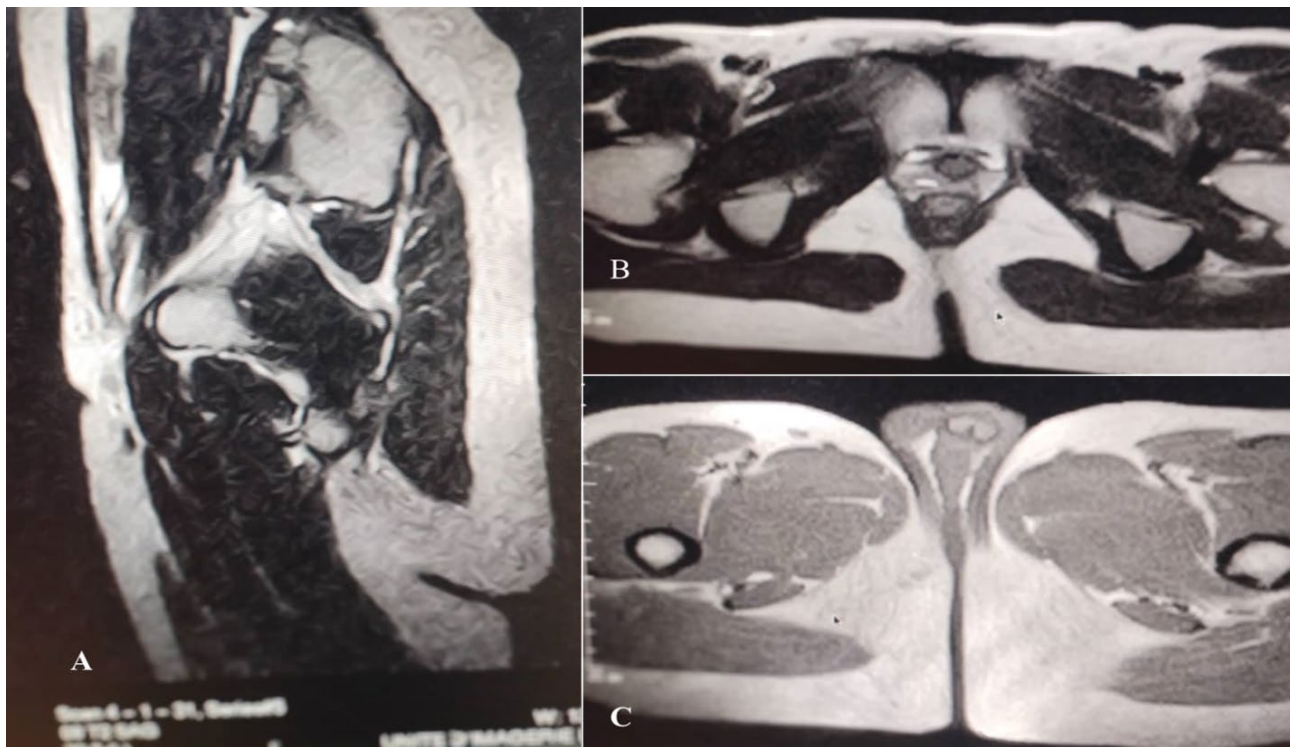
MRI in sagittal T2 sequence; axial and axial T1 showing the presence of the uterus in (A), the prostate in (B) and the presence of a right testicle (C).
